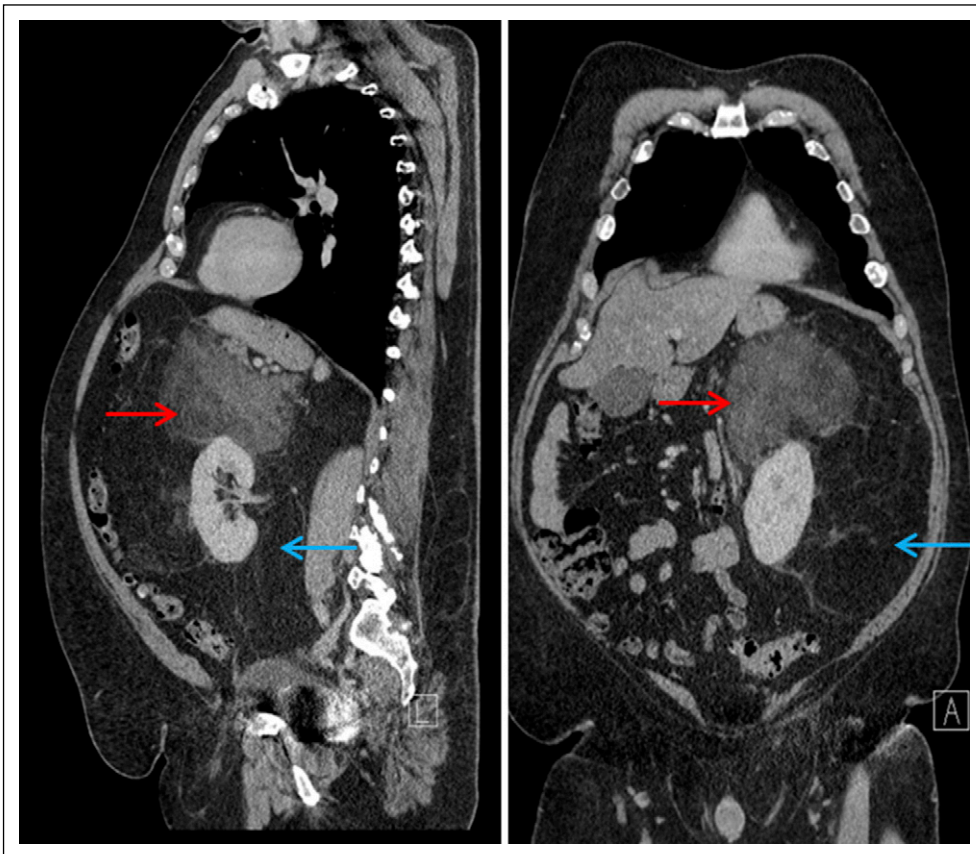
Radiologic appearance of retroperitoneal well-differentiated/dedifferentiated liposarcoma. Sagittal and coronal precontrast computed tomography images of a large liposarcoma expanding the retroperitoneum and encasing and displacing the left kidney. The blue arrow denotes a well-differentiated tumor, which shares a similar appearance to normal fat, extending inferiorly to the pelvic brim. The red arrow denotes a complex, ill-defined solid component of mixed attenuation, representing an area of dedifferentiated disease superior to left kidney.
